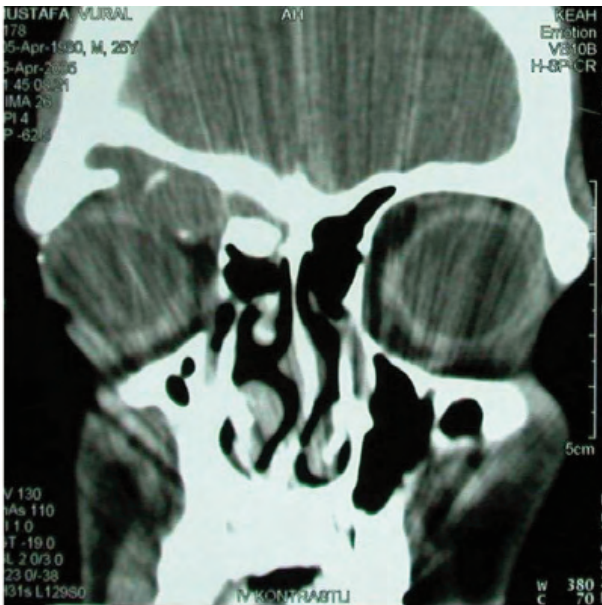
Preoperative coronal CT scan of the patient.
